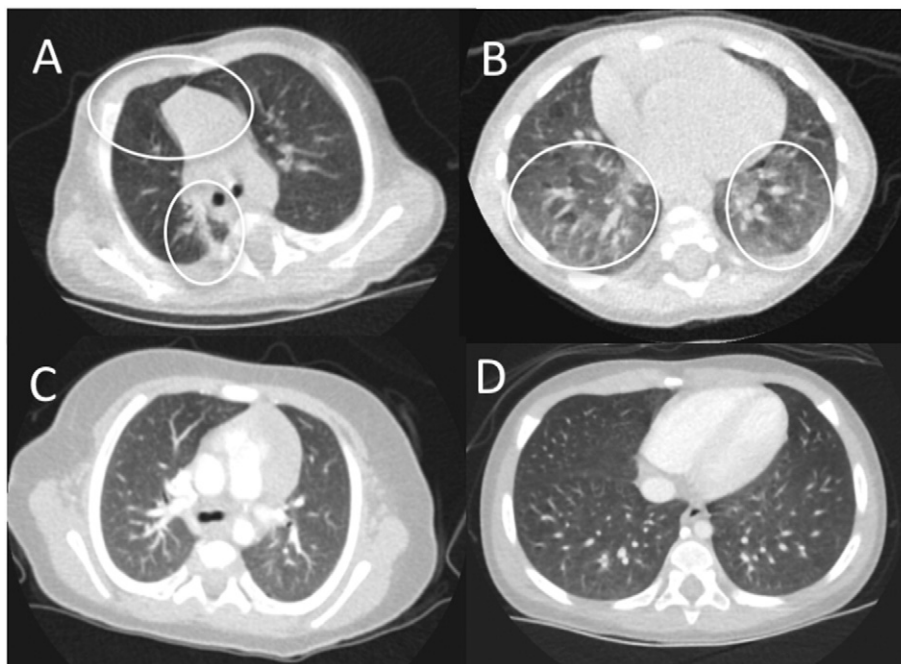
Examples of CT images at respectively 10 weeks and 13 months from infants with CF (panels A and B) and control infants (panels C and D). Panel A shows, in a 10-week old infant with CF, important abnormalities in air trapping with distension and junction of the 3 anterior parts of the lung normally occupied by the thymus, and presence of atelectasis in the right posterior field of the lung. Panel B shows air trapping with mosaic in the 2 main posterior fields of the lung.
